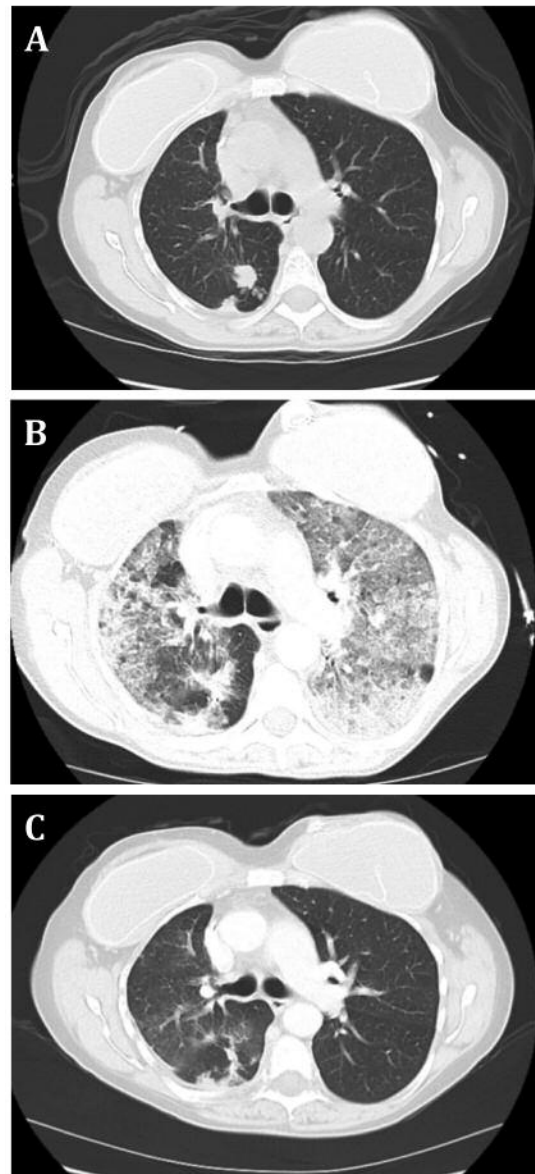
Chest CT of osimertinib-induced pneumonitis. Before treatment with osimertinib, a chest CT shows a mass at the right lung base and multiple nodules in the right lower lung (A). Three weeks after osimertinib initiation, a chest CT shows new diffuse bilateral ground glass opacities (B). Four months after rechallenging with osimertinib and steroids, a chest CT shows no evidence of recurrence of pneumonitis (C).
